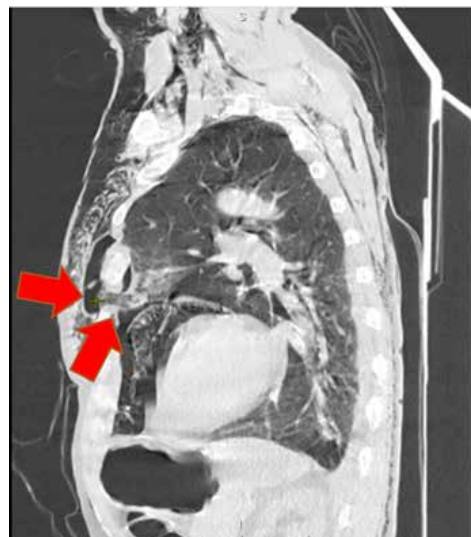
Sagittal view of chest computed tomography image that shows the left lung that herniates through a chest wall defect (red arrows).
